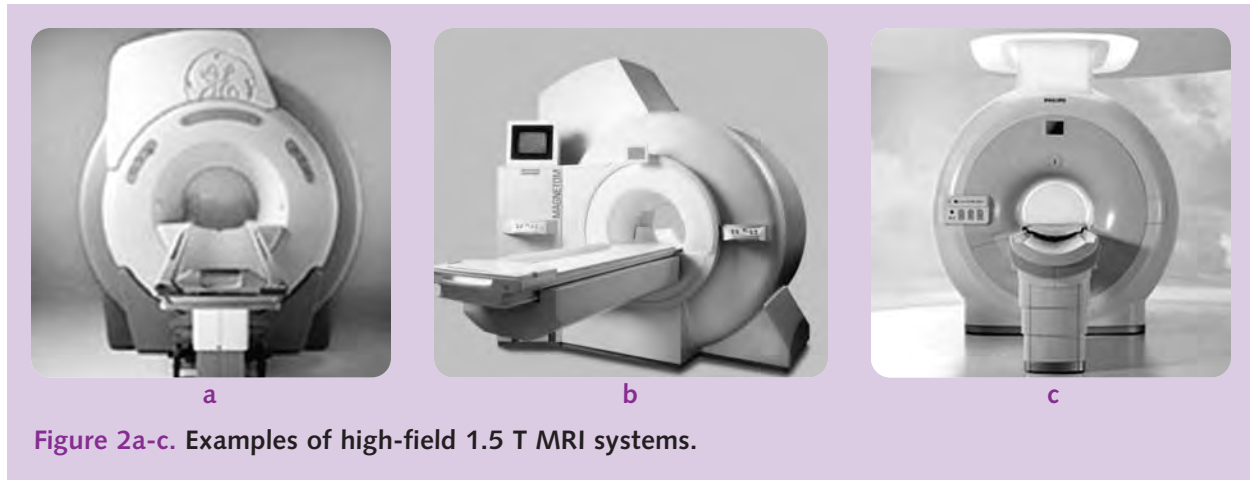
Examples of high-field 1.5 T MRI systems.
